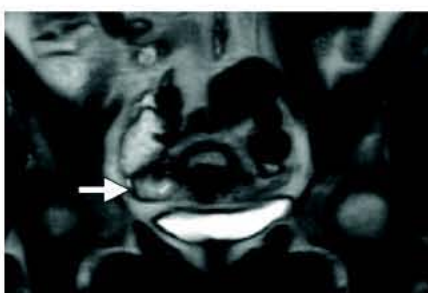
Coronal T2-weighted MRI image shows a tubal ring to the right of the uterus confirming a tubal pregnancy.
